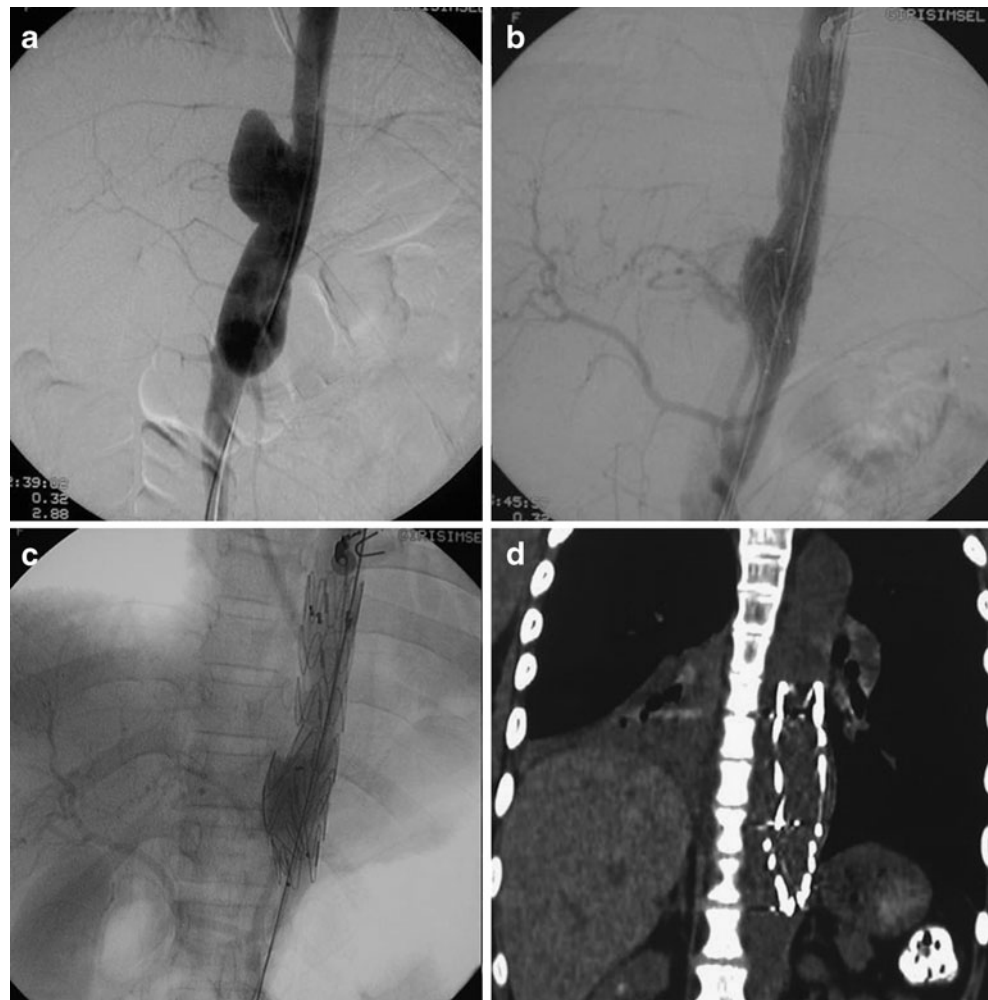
Preprocedural digital subtraction angiography (a) shows dissecting aneurysm (Stanford type B) of the thoracoabdominal aorta. An aortogram after deployment of a stent-graft (b, c) revealed a distal type I endoleak, but no additional endovascular treatment was considered. Coronal reconstructed CT image 1 month after stent-graft deployment (d)
